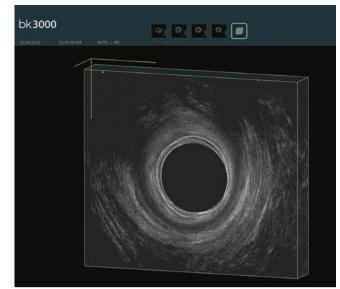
Ultrasound image of upper anal canal
